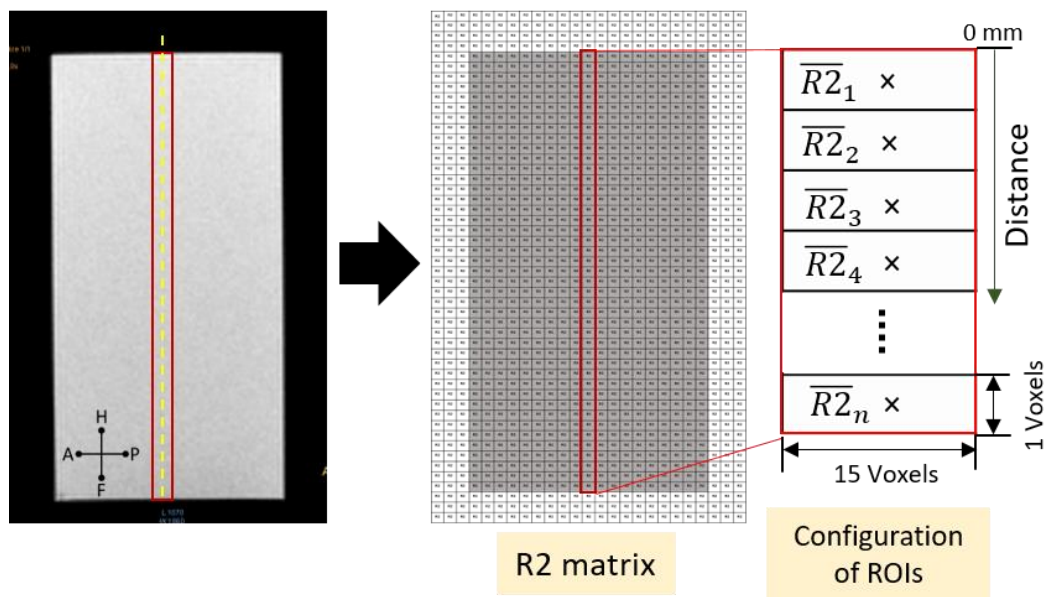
MRI image analysis to define the gel response profile, in the chosen region marked by a red rectangle, along the irradiation beam axis (marked by a yellow dashed line).
